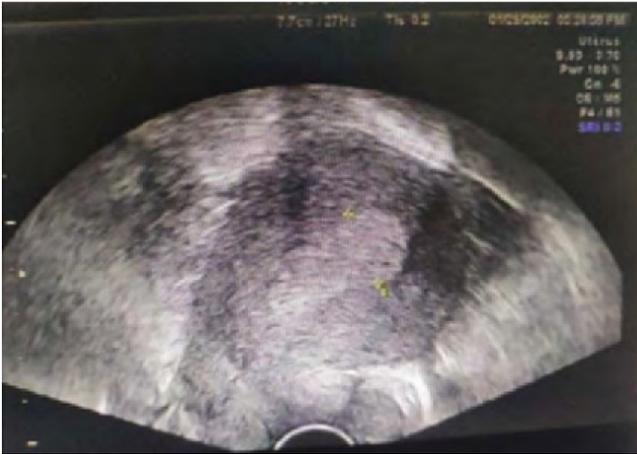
Image of transvaginal color ultrasound in patients with endometrial hyperplasia.
